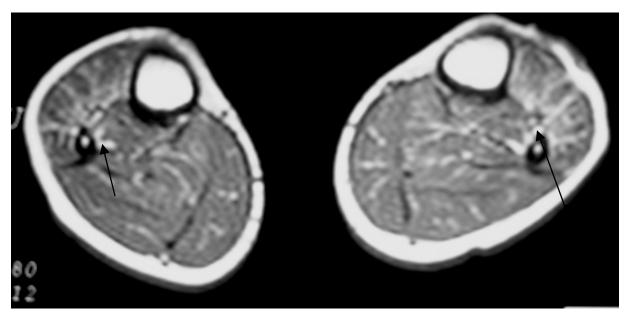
c - Case III-3. mMRI, T1-weighted images and axial sections showing fatty infiltration of muscle compartments of the anterior, posterior deep and superficial leg with less alteration of the superficial posterior compartment. Note the relative preservation of muscle compared with the previous cases.
